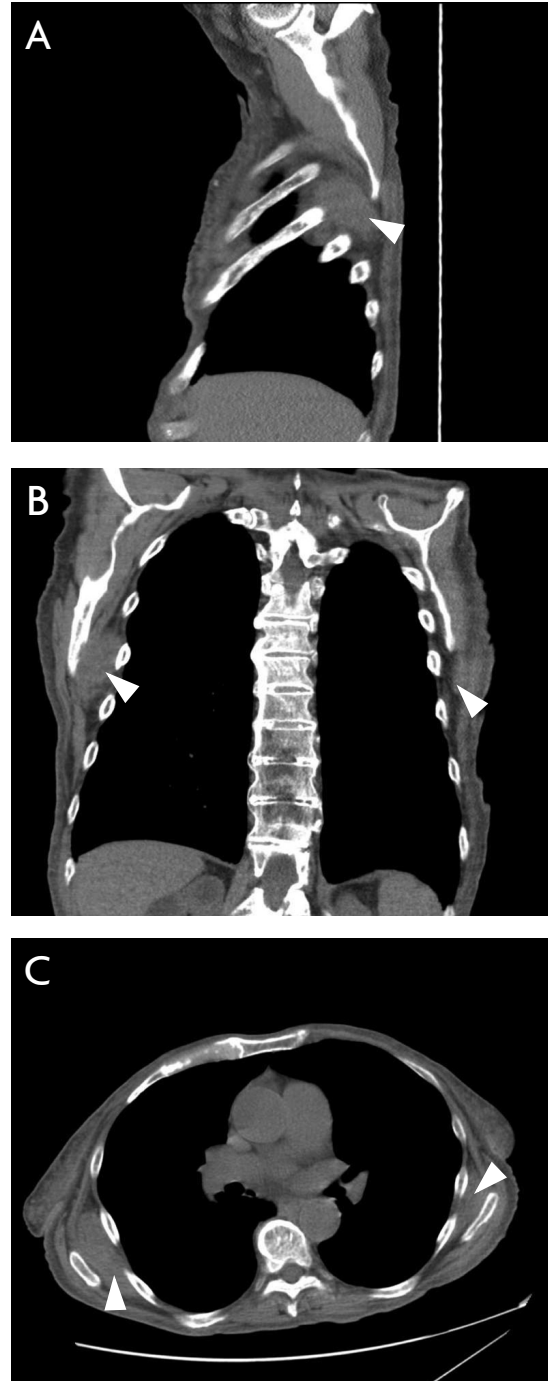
Unenhanced CT of the chest with sagittal (A), coronal (B), and transverse (C) views. Pathology indicated by arrowheads.
